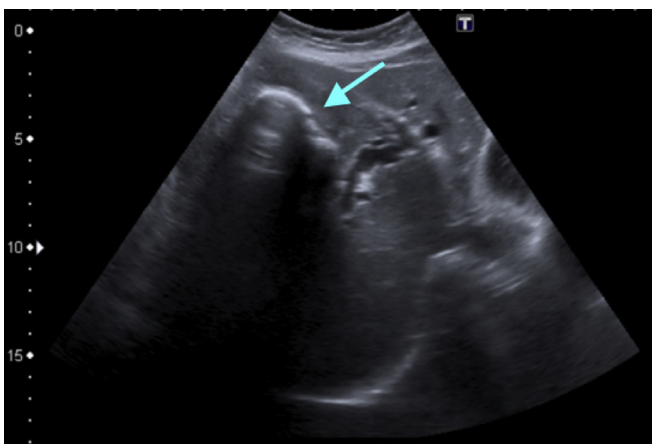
Ultrasound: porcelain gallbladder with a posterior acoustic shadow. Minimum intrahepatic bile duct dilatation. No ascites.
